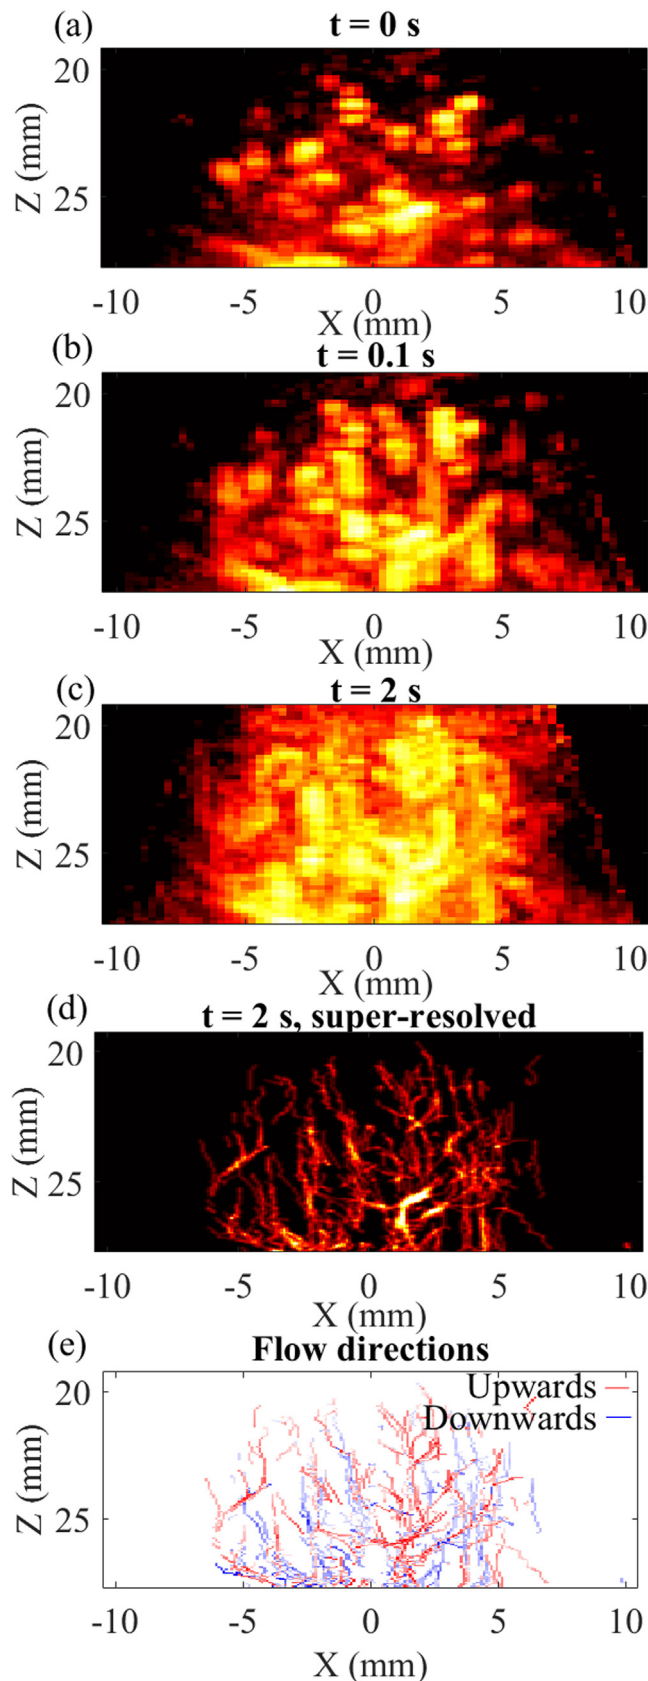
Maximum-intensity projections onto the xz plane of power Doppler volumes after accumulation in time. (a) At $t = 0$ s (or single frame), single microbubbles can still be distinguished. As the accumulation time increases, the sum of locations where the sparse bubble population have been maps out the vasculature (b, c). The low resolution of the power Doppler volumes makes it
